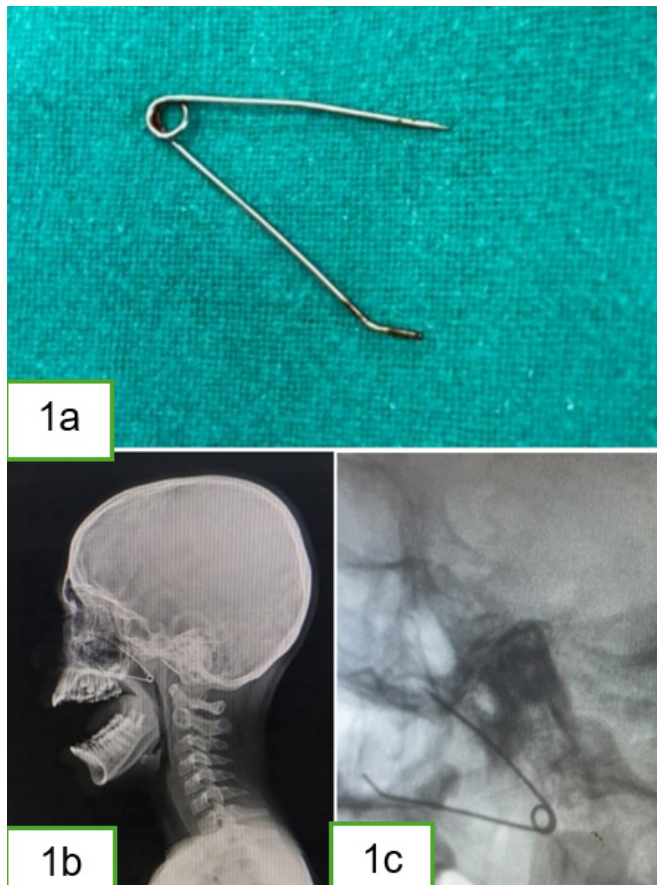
(a) Showing the open safety pin after removal (b) showing the preop Xray (c) showing intra-op C-arm done to confirm that the object has not been displaced.
